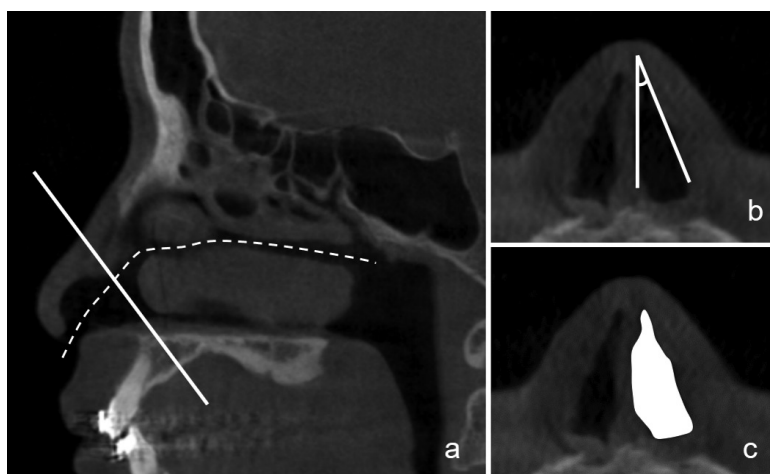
Measurements of the internal nasal valve angle and area at the reformatted coronal CBCT image: (a) A sagittal view shows the estimated acoustic axis (dotted line). A reformatted coronal plane perpendicular to the estimated acoustic axis was chosen to be 1 mm anterior to the head of the inferior turbinate; (b) a reformatted coronal plane showed the internal nasal valve angle; (c) a reformatted coronal plane shows the internal nasal valve area.
